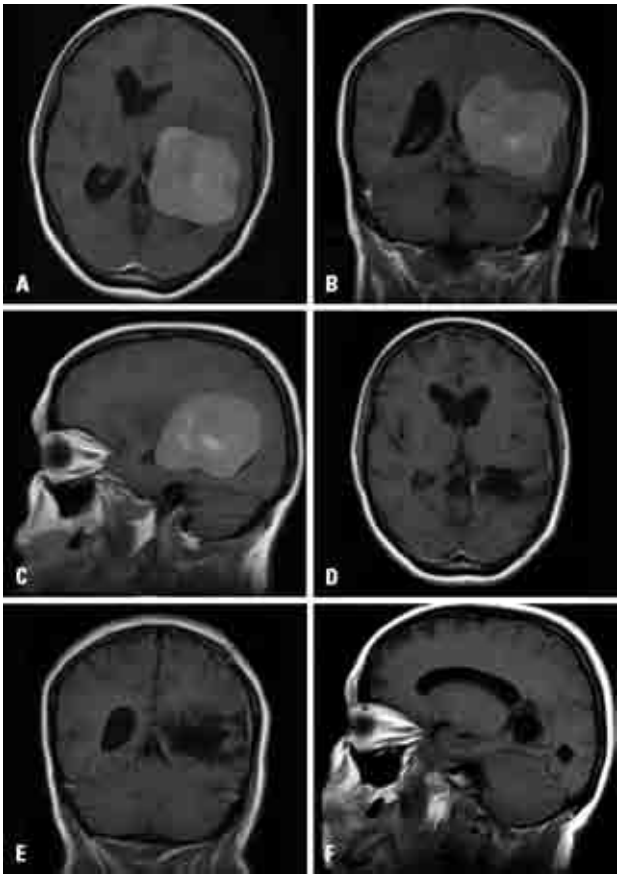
Case 2. A 50-year-old woman with a history of two weeks progressive weakness of the superior limbs, somnolence, and an episode of partial convulsion. [A, B and C] Pre-operative MRI. [D, E and F] Post-operative MRI after 8 months.
